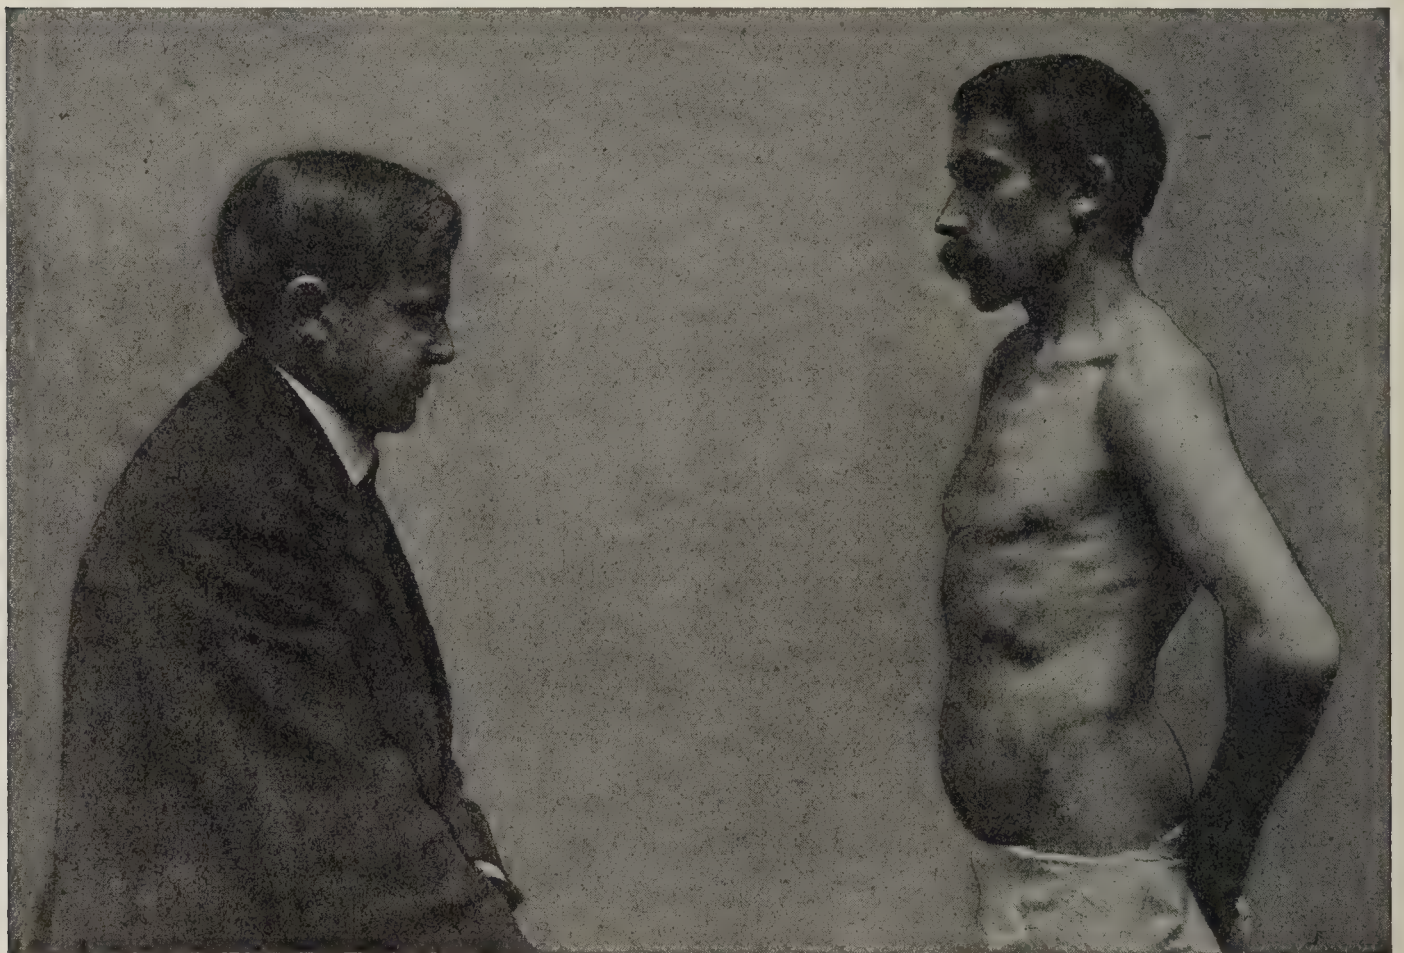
INSPECTION OF THE CHEST AND ABDOMEN. Patient standing.
